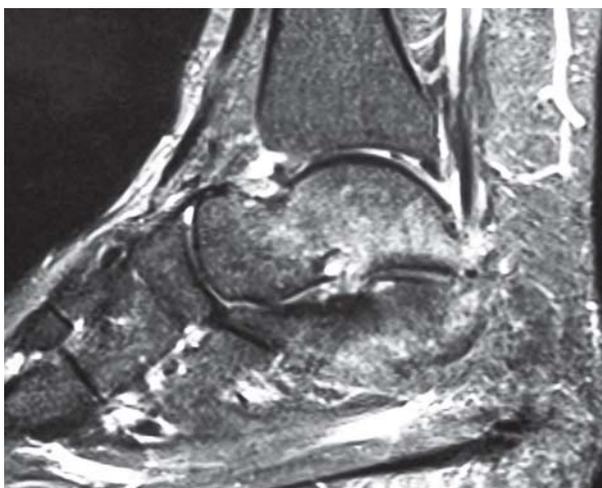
T2-weighted MRI showing high signal in the talus
